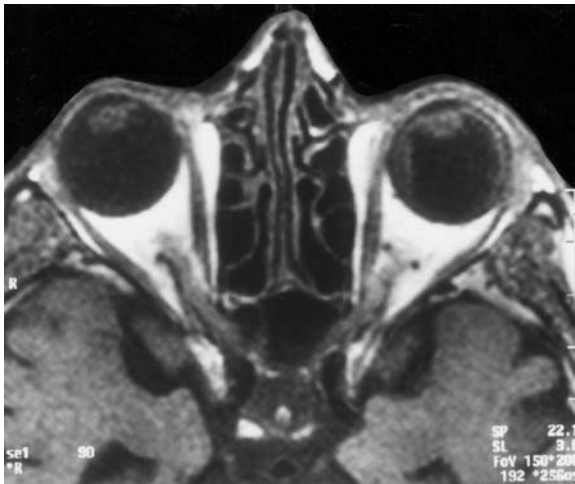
A 75-year-old woman with paroxysmal glaucoma. Diagnosis: choroidal detachment of the left globe. MRI: a Axial T1-weighted image, showing the bilateral hyperintense layer of the left choroid, enhancing after i.v. gadolinium in (b) corresponding contrast-enhanced, T1-weighted view. c Corresponding proton density image with typical fluid signal enhancement and characteristic shape
